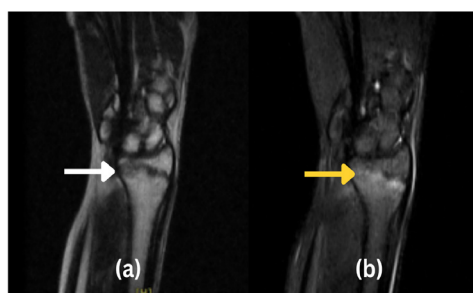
MRI of the left wrist. Image (a) is T1 weighted image showing fraying of the metaphyseal plate of distal radius (white arrow). Image (b) is T2 weighted image showing increase signal intensity at metaphyseal plate of distal radius indicating Salter Harris type 1 injury
